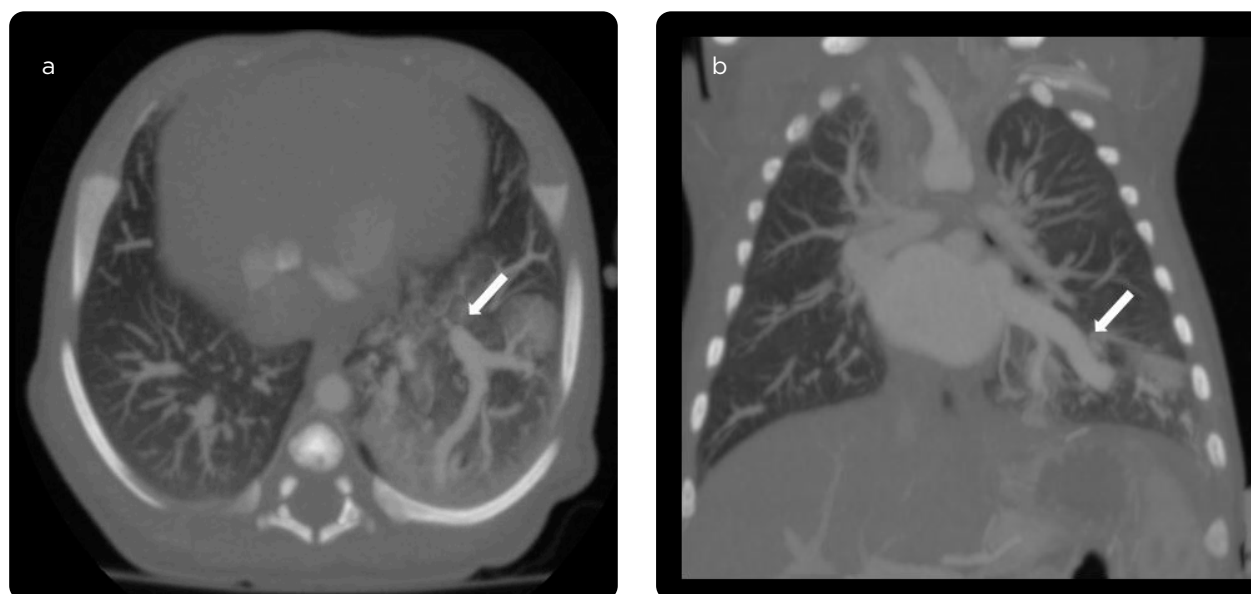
Chest CT with contrast medium, acquisition in venous phase. a) Axial reconstruction. b) Coronal reconstruction. Venous drainage to an inferior lobar vein with connection to the left atrium.
